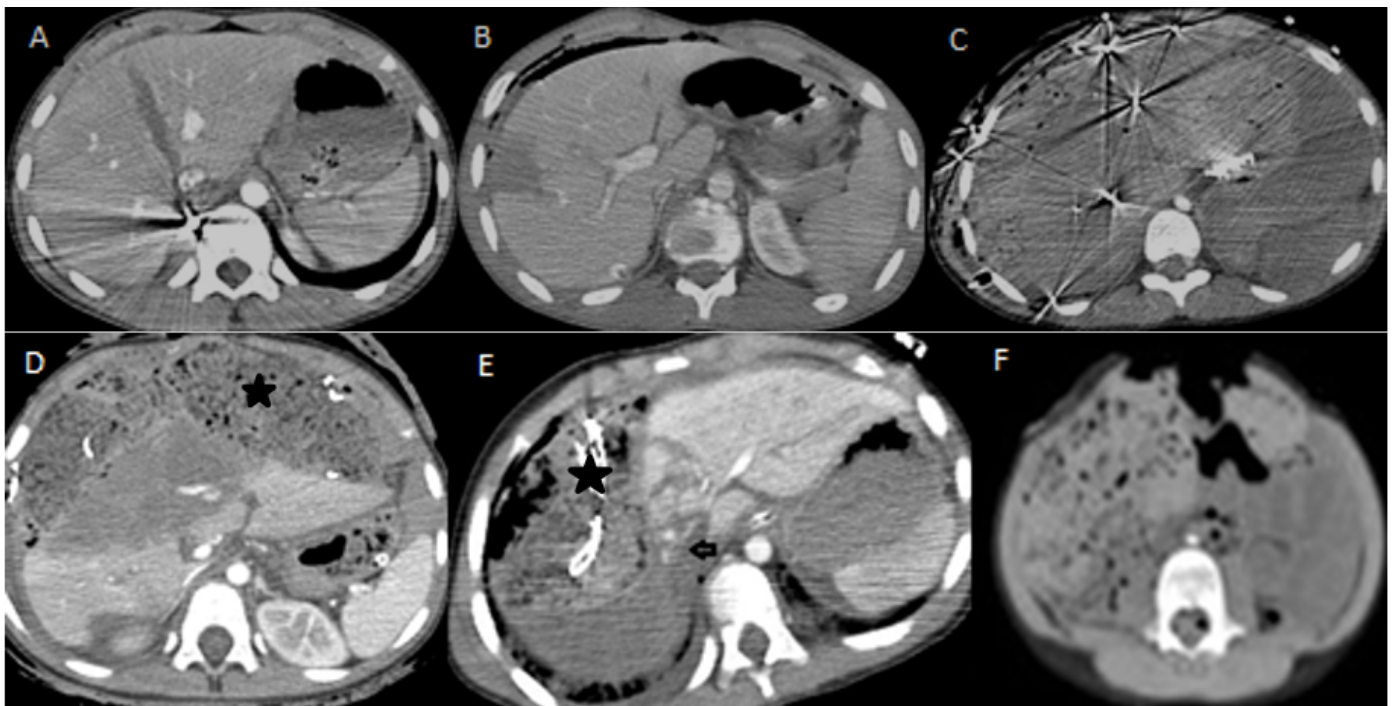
Lesion patterns on CT images. A. A laceration with parenchymal extension of more than 3 cm, and shrapnel particle, B. Intraparenchymal hematoma with laceration, C. Multiple shrapnel particles in liver parenchyma, D. Oversized devascularized area and contrast extravasation, buffer placed in Syria for bleeding control (blackstar), E. Large devascularized area in the right lobe of the liver, hepatic vein injury (blackarrow) and buffer placed in Syria for bleeding control (black star), F. Packing with open abdomen
